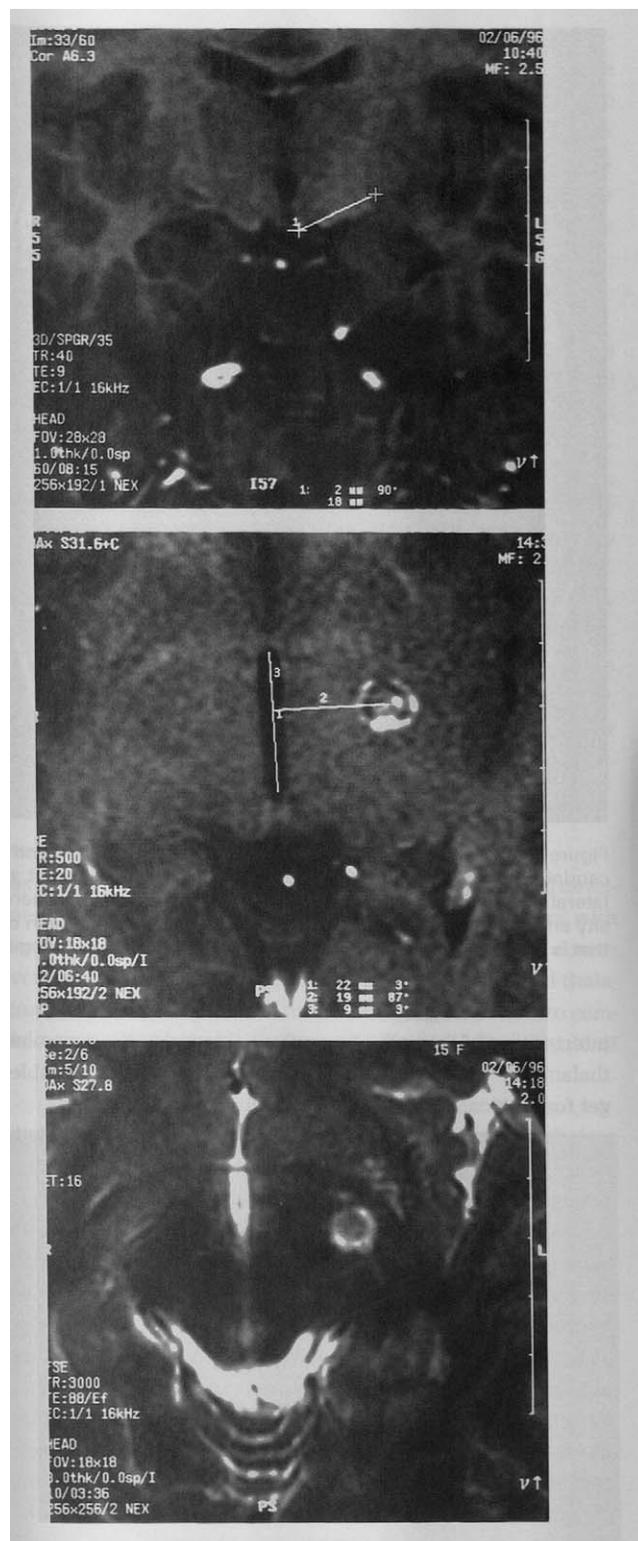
Ventroposterior pallidal lesion to control unilateral dystonia in a 14-year-old patient who developed symptoms after childhood encephalitis. This lesion was successful in improving her torticollis and dyskinetic movements in her extremities. Target determination was based on mammillary body depicted on a coronal image perpendicular to the anterior-posterior commissure line (*top*). A gadolinium-enhancing lesion on a  $T_1$ -weighted MRI scan at the level of the anterior commissure-posterior commissure plane is shown. Notice the measurements of the lesion location based on anterior commissure-posterior commissure landmarks (*middle*). Lesion seen on a  $T_2$ -weighted image at its most ventral level (*bottom*).
